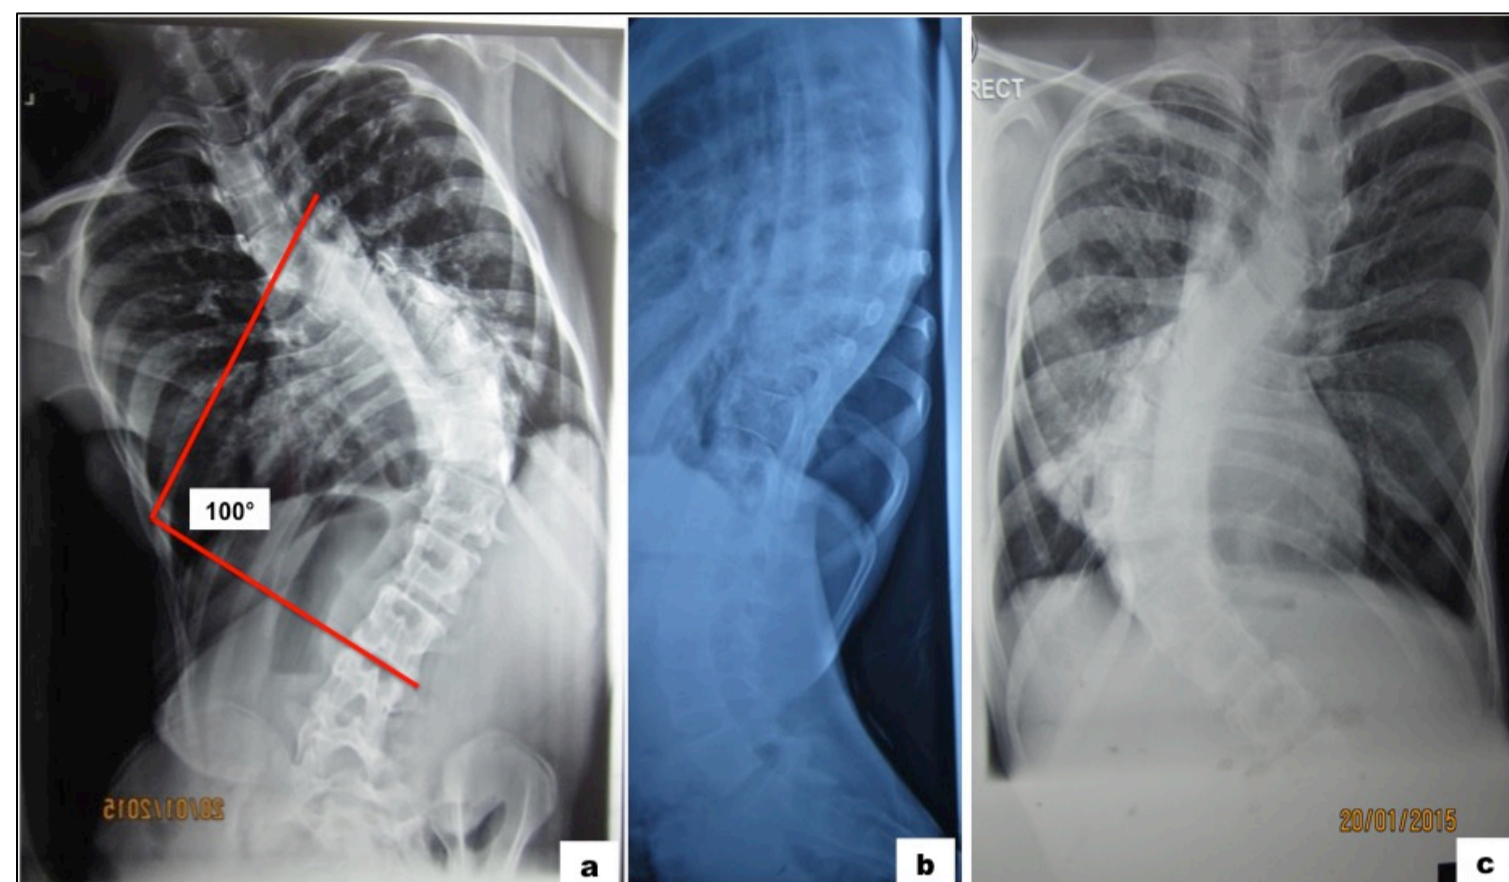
Right thoracolumbar curve with Cobb's angle 100° (a,b). Pre-operative chest radiograph (c).
